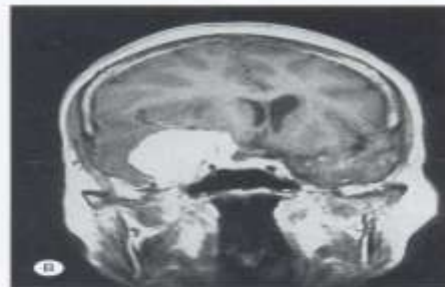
Gadolinium-enhanced MR image of a medial sphenoid wing meningioma in axial (A), coronal (B), and sagittal (C) planes.
